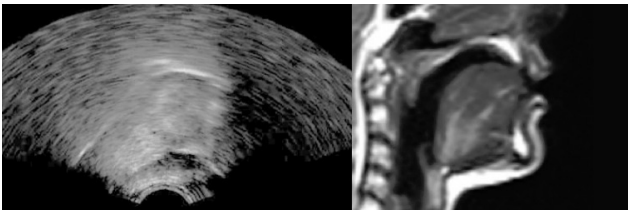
Comparison of Ultrasound (on the left) and MRI (on the right) still frames of the pronunciation of /t/. Adapted from “seeingspeech”, available from: <https://www.seeingspeech.ac.uk/mri-and-uti/>.
